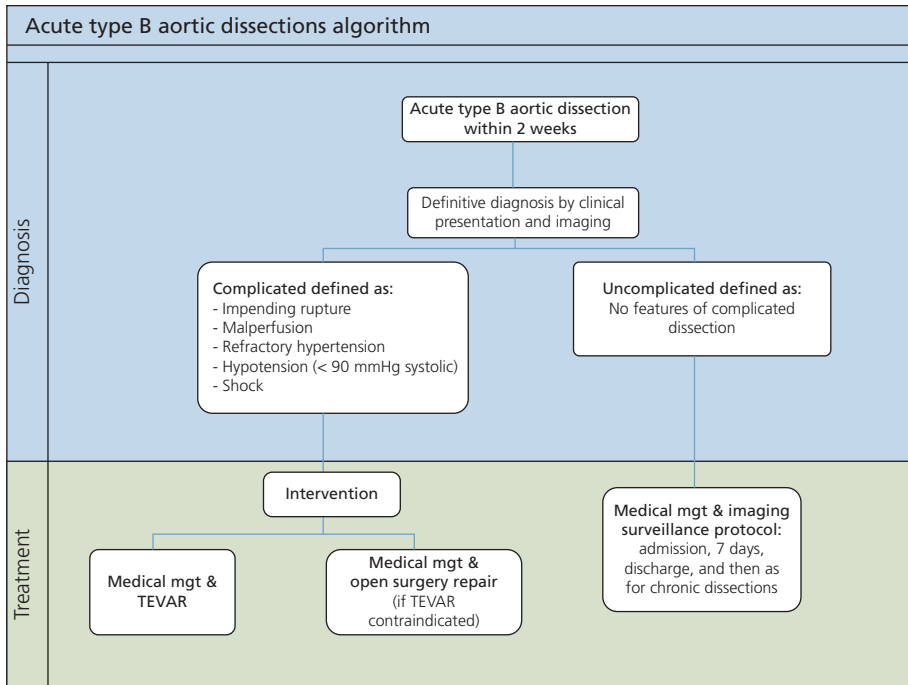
Interdisciplinary expert consensus document. Algorithms for management of acute, subacute, and chronic type B aortic dissections. TEVAR indicates transthoracic endovascular repair.
